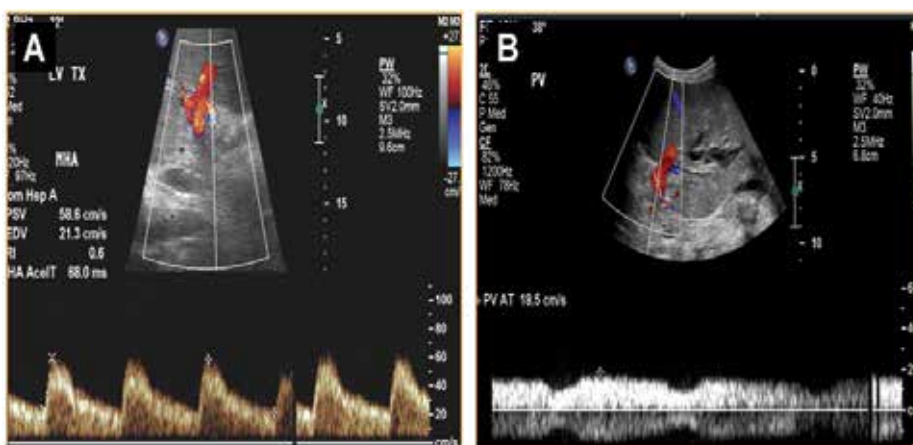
Normal Doppler US study of the hepatic artery and portal vein after liver transplantation. (A) Pulsatile, low resistant hepatopetal flow in hepatic artery with velocity of 58.6 cm/s. (B) Phasic hepatopetal flow in portal vein with velocity of 18.5 cm/s
